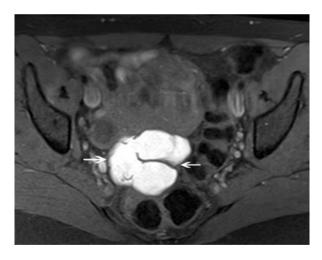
Hematosalpinx. Axial T1-weighted MR with fat saturation shows a large, posterior hematosalpinx (arrows) due to endometriosis
